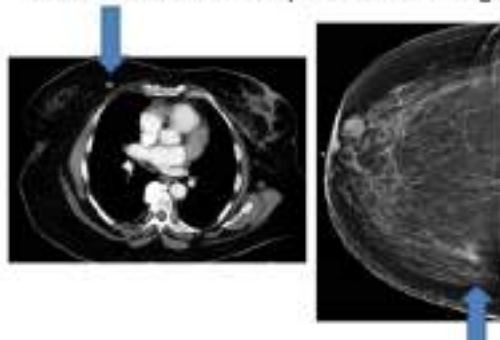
Medial Right Breast Mass is much easier to see on CT compared to mammogram
